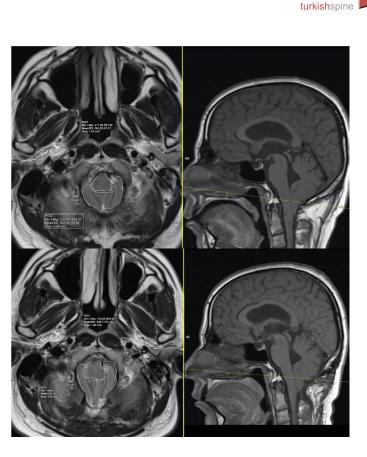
Preoperative and postoperative measurements changes In a patient diagnosed with Chiari malformation type I (CMI), BA and CTA measurements were observed in pre-operative and post-operative MRI scans. In the pre-operative MRI, the BA was measured to be 1.42 cm², while the post-operative BA increased to 1.90 cm². Similarly, the pre-operative CTA was 3.88 cm² and expanded to 5.94 cm² in the post-operative MRI. Importantly, these measurements were taken at a consistent axial section level and angle in both pre-operative and post-operative scans
